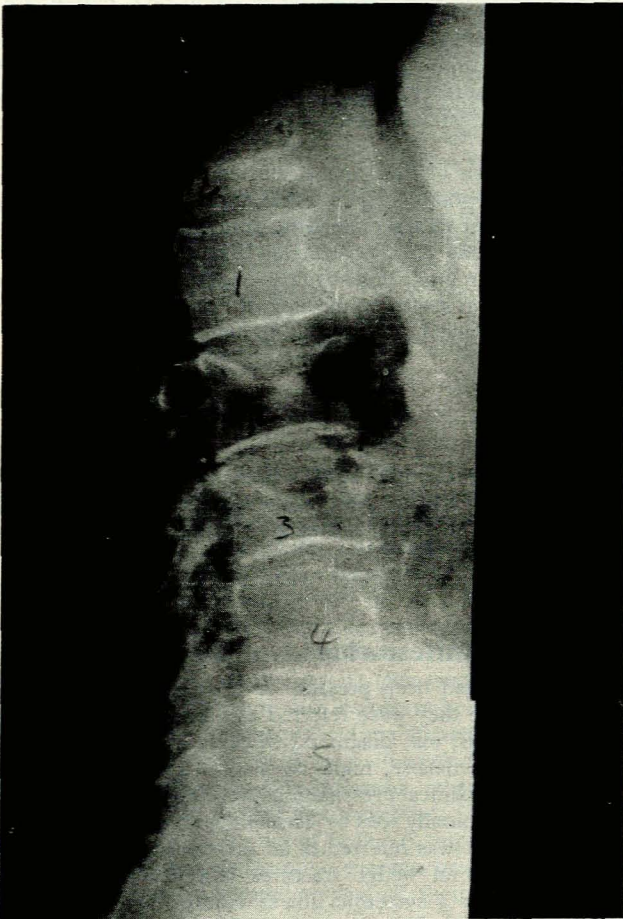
Lateral radiograph of lumbar spine revealing osteoporosis and wedge compression fractures of T12 and L2, 3 in a patient with hepatic osteodystrophy and PBC.
